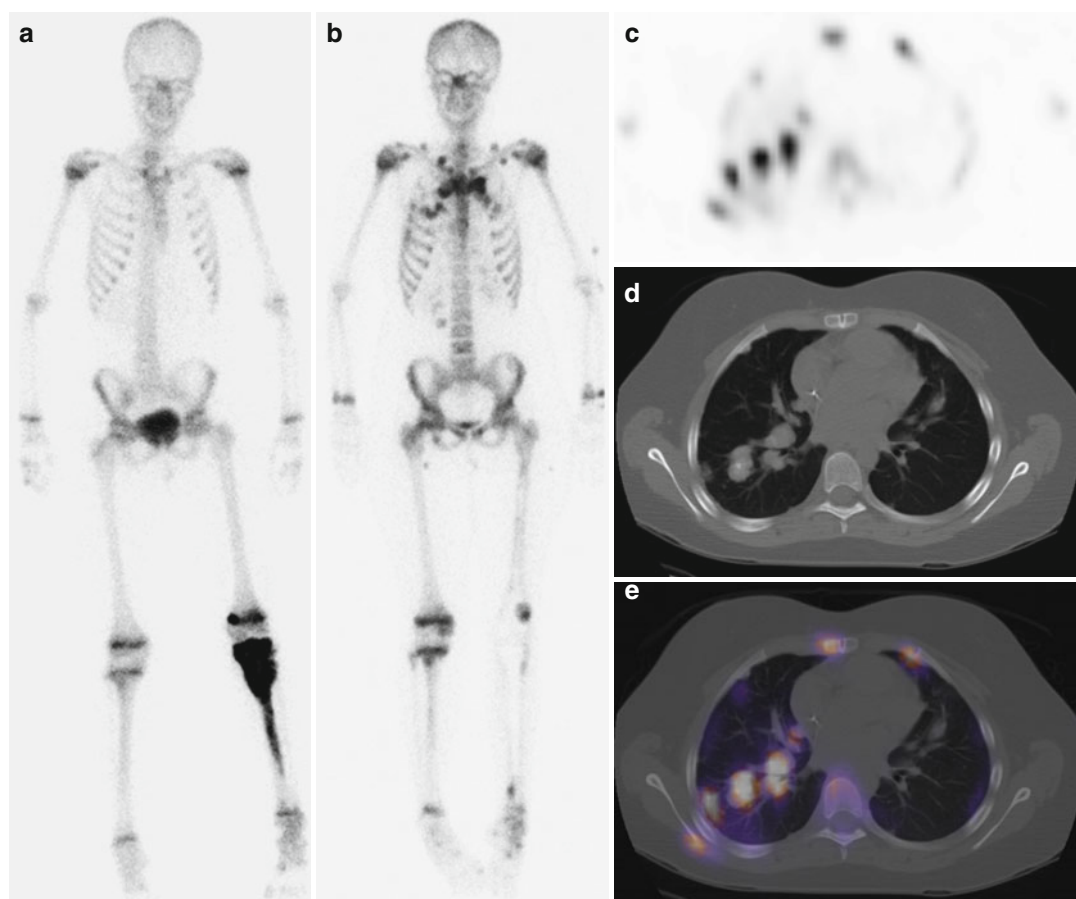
Osteosarcoma complicated by widespread metastases demonstrates that bone scan and chest CT are complementary for finding metastases. A 14-year-old girl was diagnosed with osteosarcoma of the left tibia. (a) Initial ^{99m}Tc -MDP bone scan shows intense uptake in an expansile lesion of the proximal left tibia, but no metastases. (b) One year after chemotherapy and surgical resection with placement of a prosthesis, bone scan shows numerous sites of abnormal osseous and soft tissue uptake in the torso that are concerning for metastases. In the legs, increased cortical bone uptake adjacent to intramedullary rods in the left femur and tibia is an expected finding, but abnormal focal uptake in the distal
